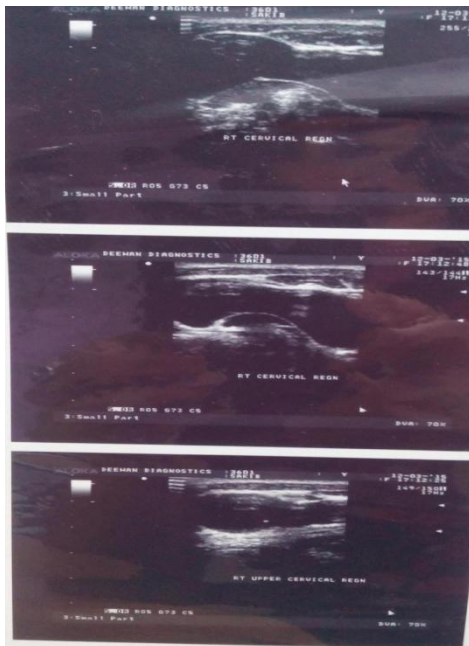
Ultrasound Images of Lymphangioma
